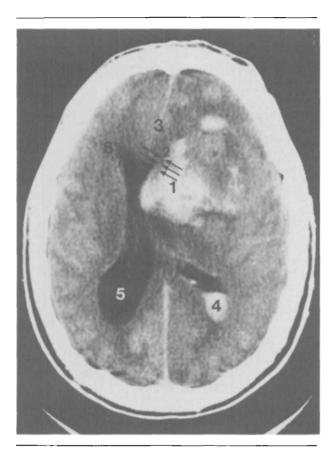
Computed tomography scan of the head of a patient following subarachnoid haemorrhage from a middle cerebral artery aneurysm. Note the presence of an intracerebral haematoma on the right (1) with mass effect indicated by the obliteration of the anterior right lateral ventricle (2 with arrows) and midline shift (3). A ventricular "cast" of blood is present in the posterior horn of the right lateral ventricle (4) and dilatation of the left lateral ventricle (5) with hypodensity in the periventricular tissue surrounding the anterior horn (6) suggest the presence of acute hydrocephalus.
